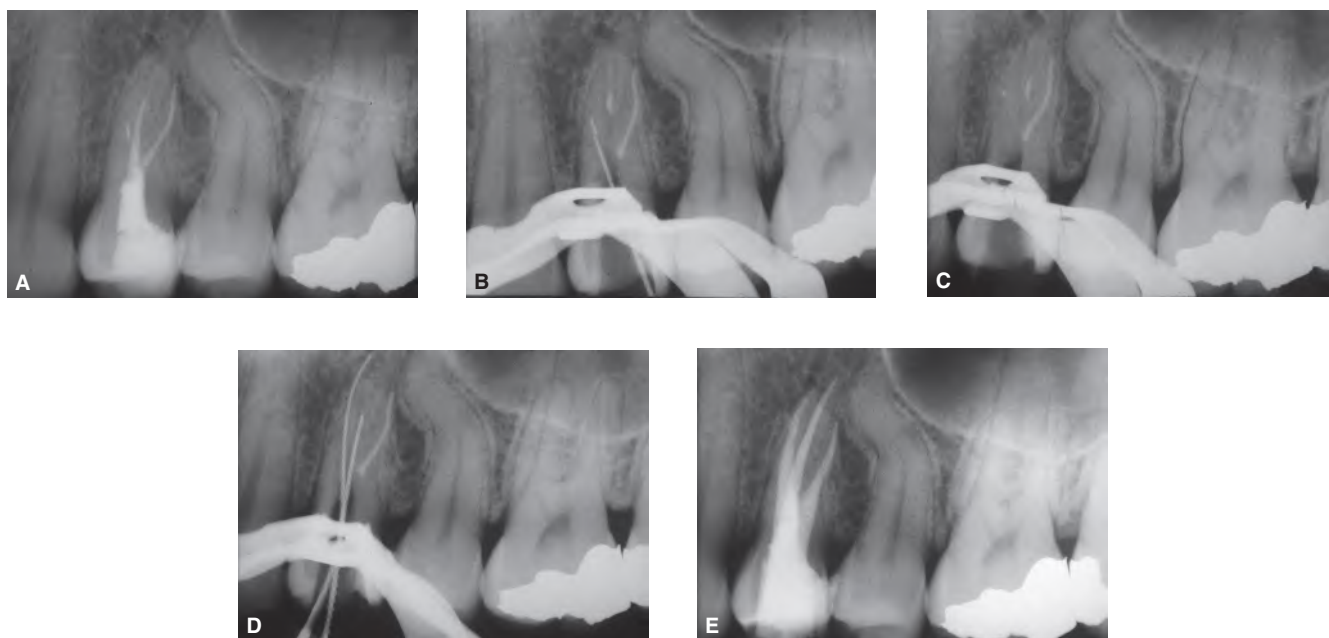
A.* Preoperative radiograph of a three-rooted maxillary premolar with a failed root canal treatment and a separated NiTi instrument in the MB canal. *B.* A conservative radicular access was created up to the instrument. *C.* A thin ultrasonic tip was used to abrade the instrument. *D.* The residual fragment was bypassed. A ledge was present in the palatal canal. *E.* Postoperative radiograph showing the retreated case. (Courtesy of Dr. Dominique Martin, Paris, France.)
